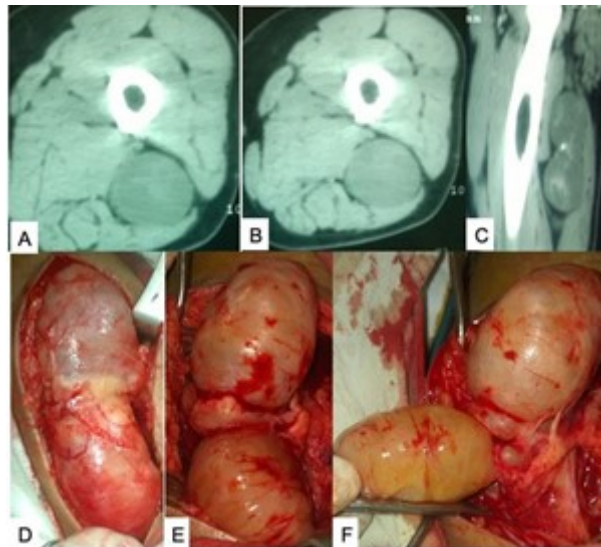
(A–C) CT scan of thigh showing a dumbbell-shaped femoral nerve schwannoma. (D–F) Sequential images of the removal of the schwannoma. Source: Figure by authors.
